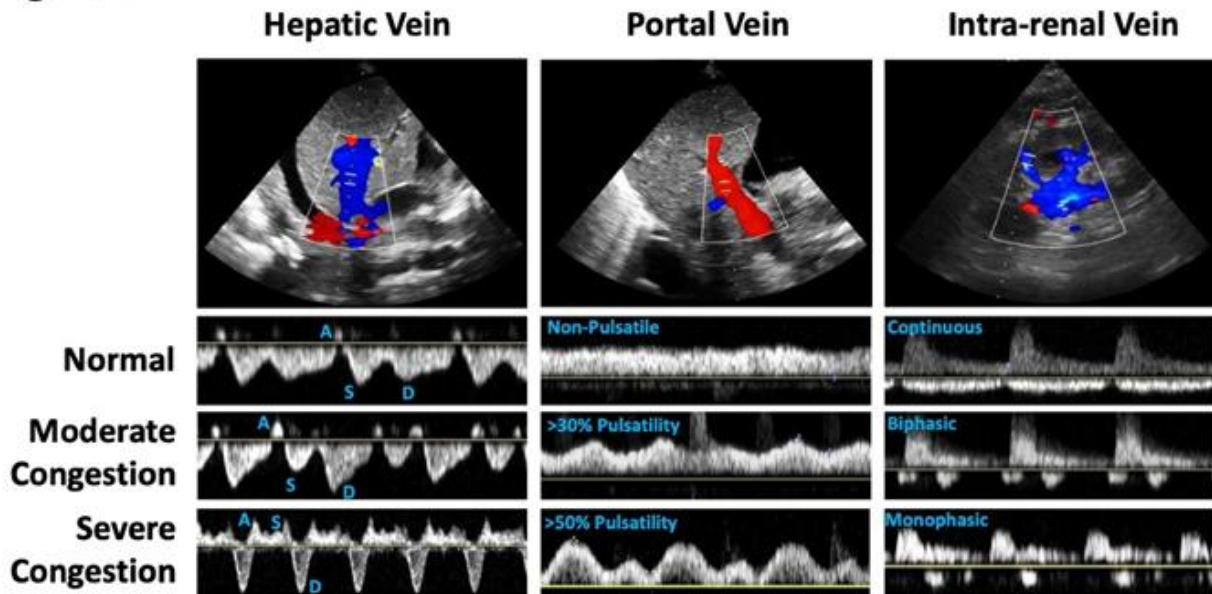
1 Doppler abnormalities in the portal vein, hepatic vein, and intrarenal vein. Redisplayed here with permission under Open License from Prager et al. 2023.
